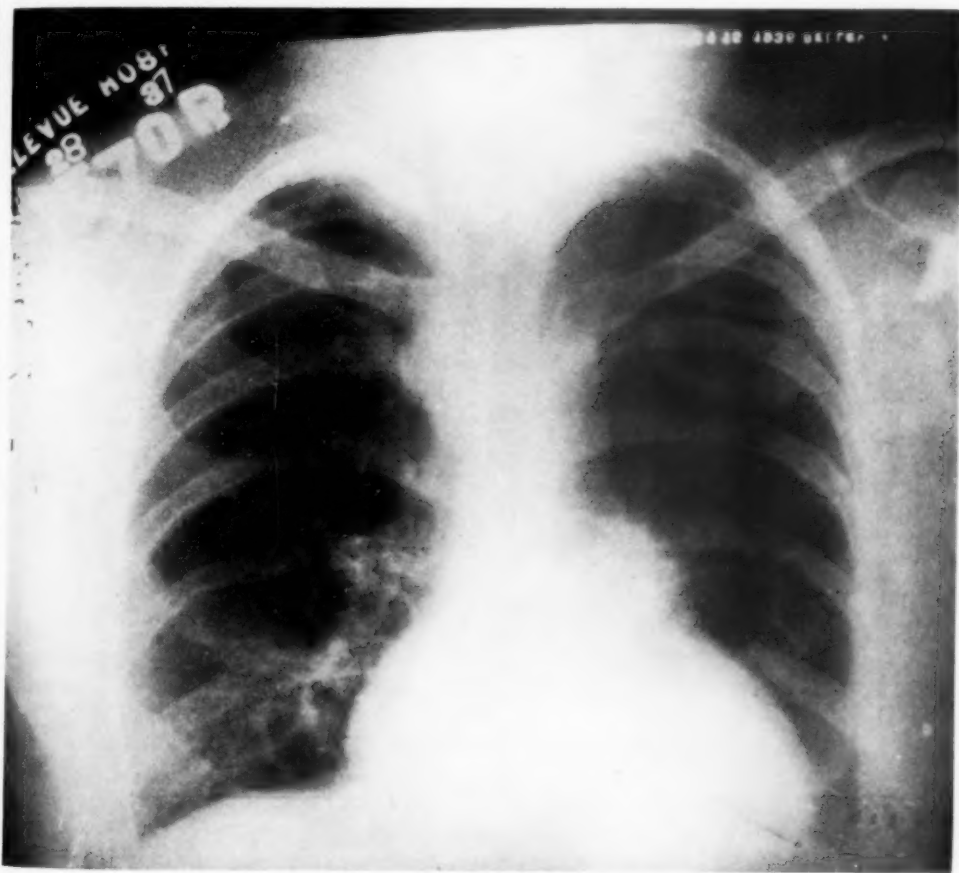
Antero-posterior roentgenogram of chest. Note absence of the aortic knob, prominent pulmonic conus and indentations of ribs.
